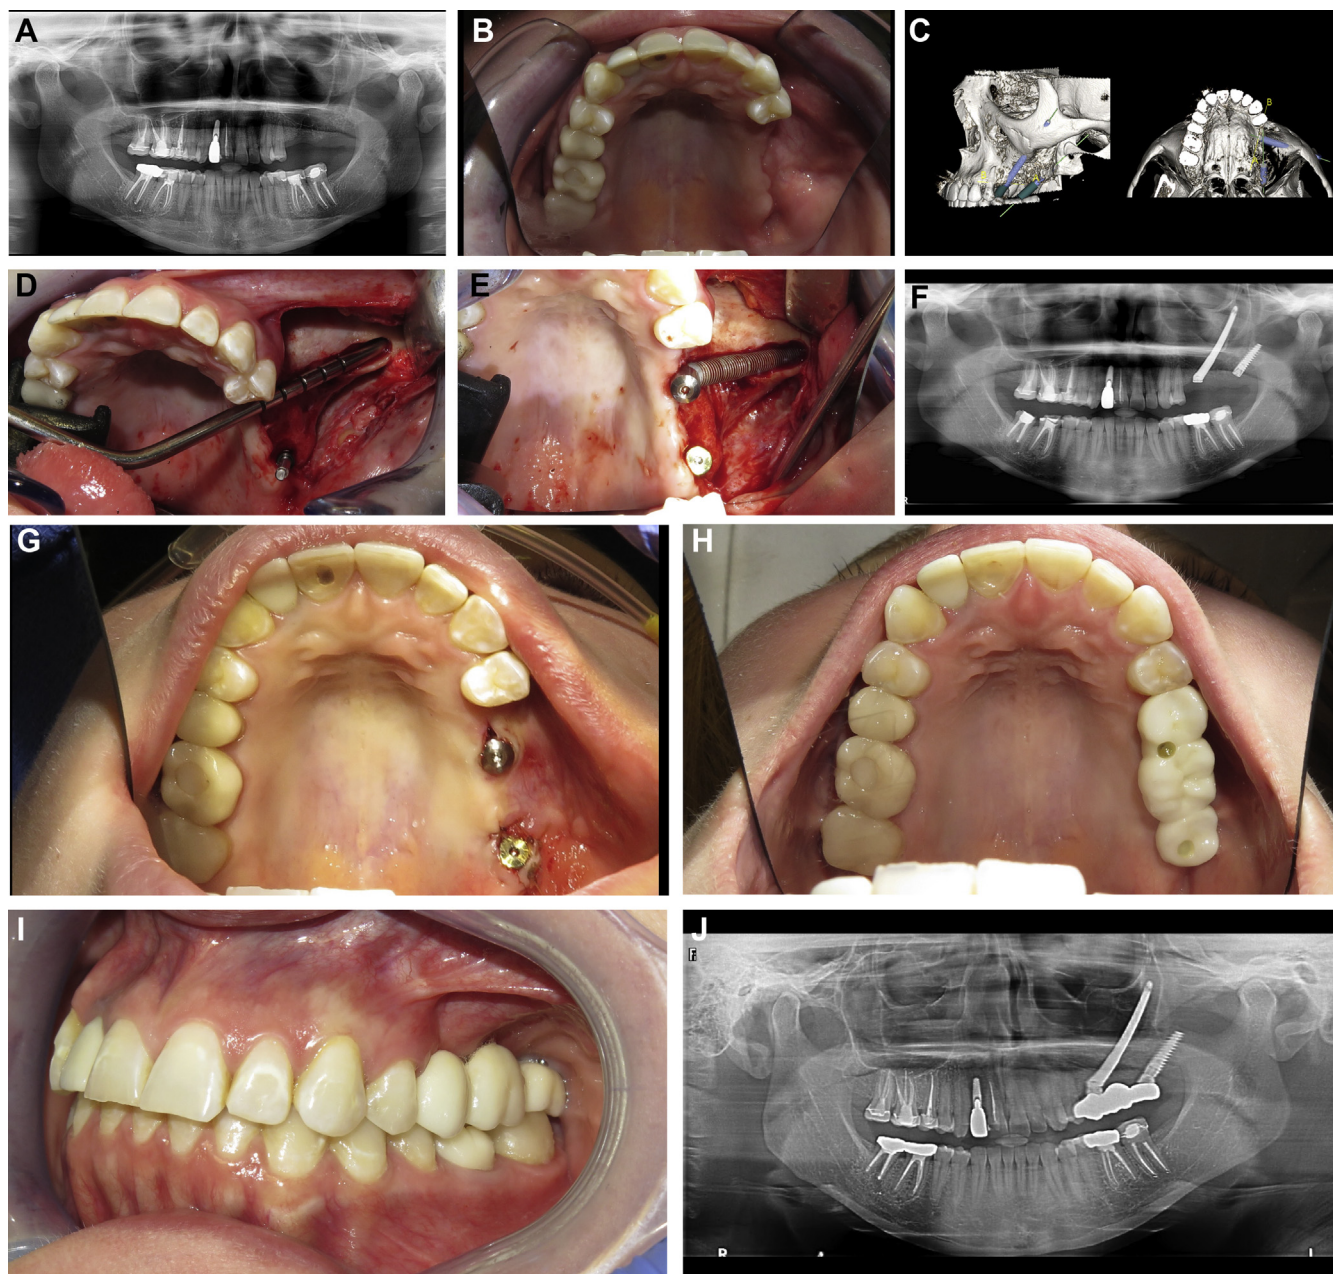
Partially edentulous patients. A 30-year-old woman referred to the authors' department after 2 previously failed sinus lifts to replace teeth 13, 14, and 15. After clinical and radiographical examination, it was determined that the patient would benefit from the placement of 1 left pterygoid implant and 1 zygoma implant around tooth numbers 13 to 1. (A) Preoperative panoramic radiograph showing missing teeth numbers 13, 14, and 15. (B) Occlusal view demonstrating a left posterior alveolar ridge defect. (C) Prosthetically driven virtual treatment plan. The pterygoid implant was planned with a custom-made drill guide, and the zygoma was planned to be placed freehand. (D) Intraoperative view. The pterygoid implant is already placed, and the osteotomy for the zygoma implant is being performed. (E) Occlusal view demonstrating the placement of the zygoma and pterygoid implant. Note the placement of both implants within the crest of the alveolar ridge. (F) Postoperative panoramic radiograph. (G) Occlusal view at the time of implant uncovering. (H) Occlusal view of the final 3-unit bridge. (I) Final occlusion. (J) Final panoramic radiograph.
